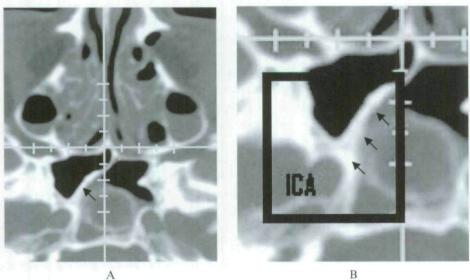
A, Axial computed tomographic scan showing the intersinus septum (arrows) and its crucial relationship to the internal carotid artery (ICA). B, Closer view.
